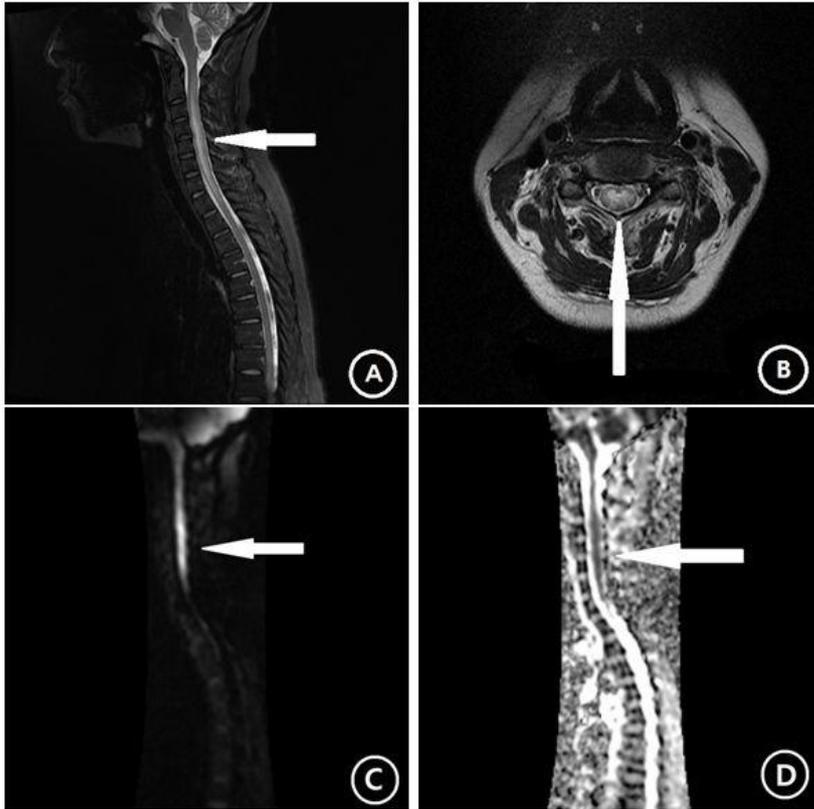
Cervical MRI was taken 5 days after the symptom onset. There are spinal cord lesions in cervical and upper thoracic level (Arrows). (A) In sagittal view, T2-weighted image showed high signal intensity from C2 to T1 level. (B) In axial view, T2-weighted image showed high signal intensity in bilateral areas of spinal cord on C4 level. (C) Diffusion-weighted image and (D) apparent diffusion coefficient image showed long extension of spinal cord infarction from C2 to T1 level.
